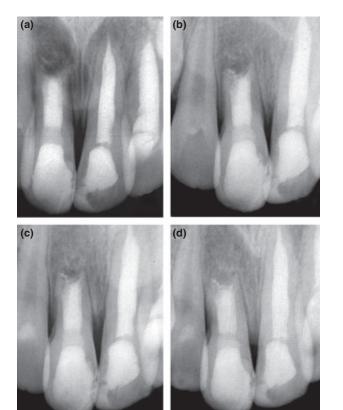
(a) Mineral trioxide aggregate (MTA) obturation of the root canal; (b) Radiographic follow-up at 6 months demonstrating stability of the resorption and periapical healing; (c) Advanced regeneration of periradicular tissues and re-establishment of the periodontal space at 12 months; (d) 24-month radiographic view, demonstrating complete healing. Periodontal ligament space can be traced along the entire root.
